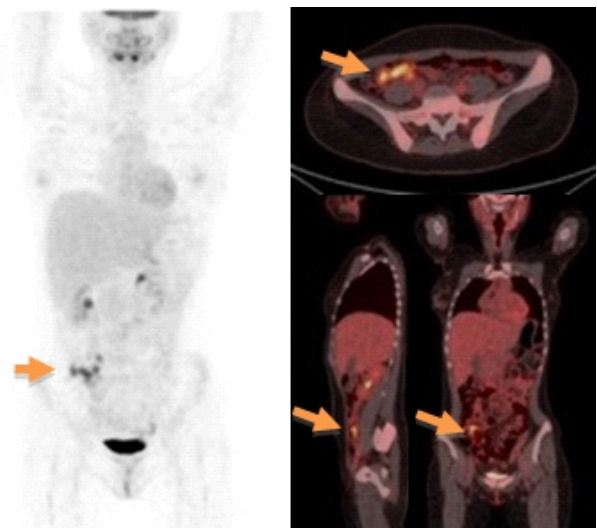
A 19 year old woman evaluated for axillary lymphadenomegaly with recent diagnosis Chron's disease. Fluorine-18-FDG PET/CT: expected and typical uptake in bowel (green arrow), relate to IBD.
